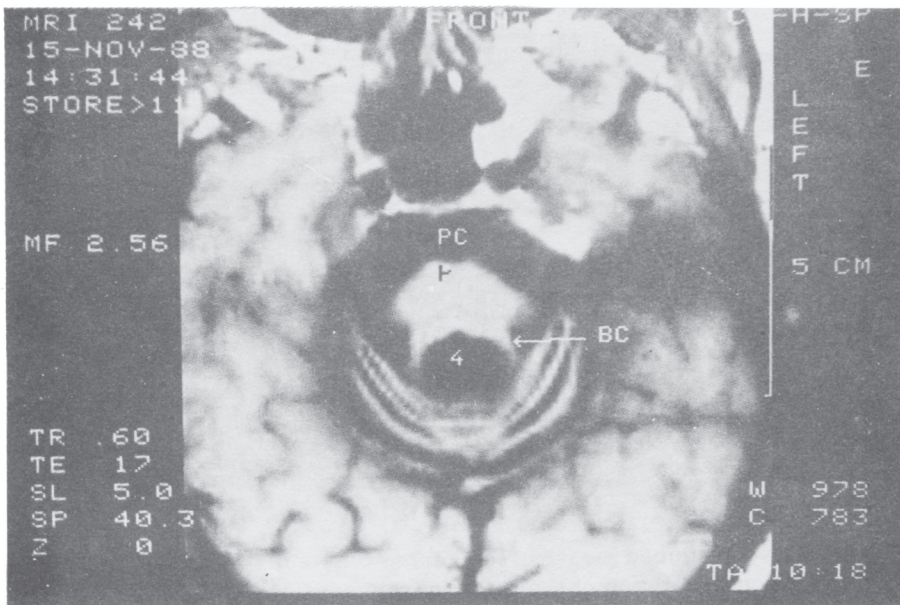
An axial section of the MRI of the same patient showing atrophy of the cerebellar vermis, brachium conjunctivum (BC) and pons (P). The pontine cistern (PC) is considerably enlarged and the fourth ventricle (4) is ballooned.
